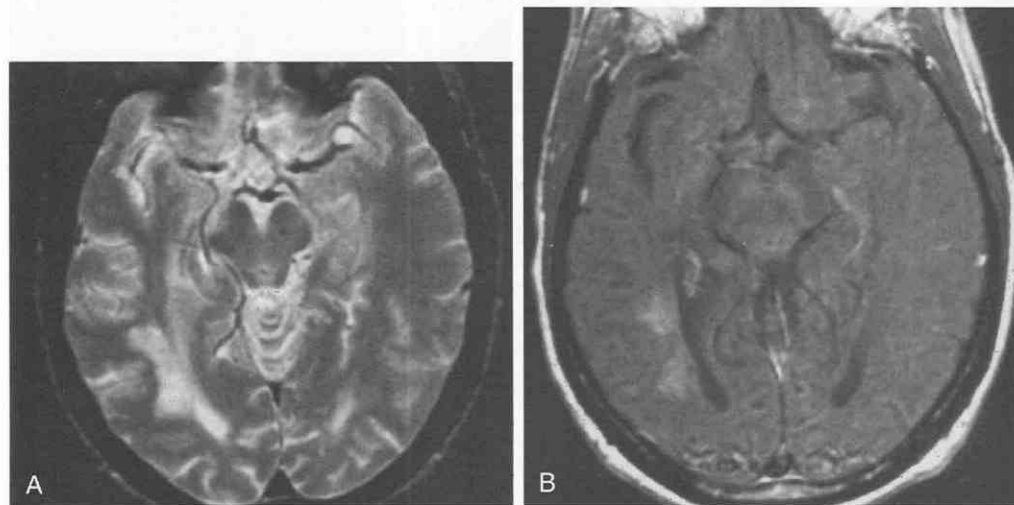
Progressive multifocal leukoencephalopathy (PML) in a 56-year-old man with human immunodeficiency virus infection and hemiparesis. *A*, Cranial T2-weighted axial MR image shows a confluent hyperintense white matter lesion adjacent laterally to the right occipital horn. Note the sparing of the overlying gray matter cortex. *B*, Magnetization transfer (MT) postgadolinium-enhanced MR axial image. Note the minimal contrast enhancement, which was not seen on CT or standard T1-weighted MR images.
